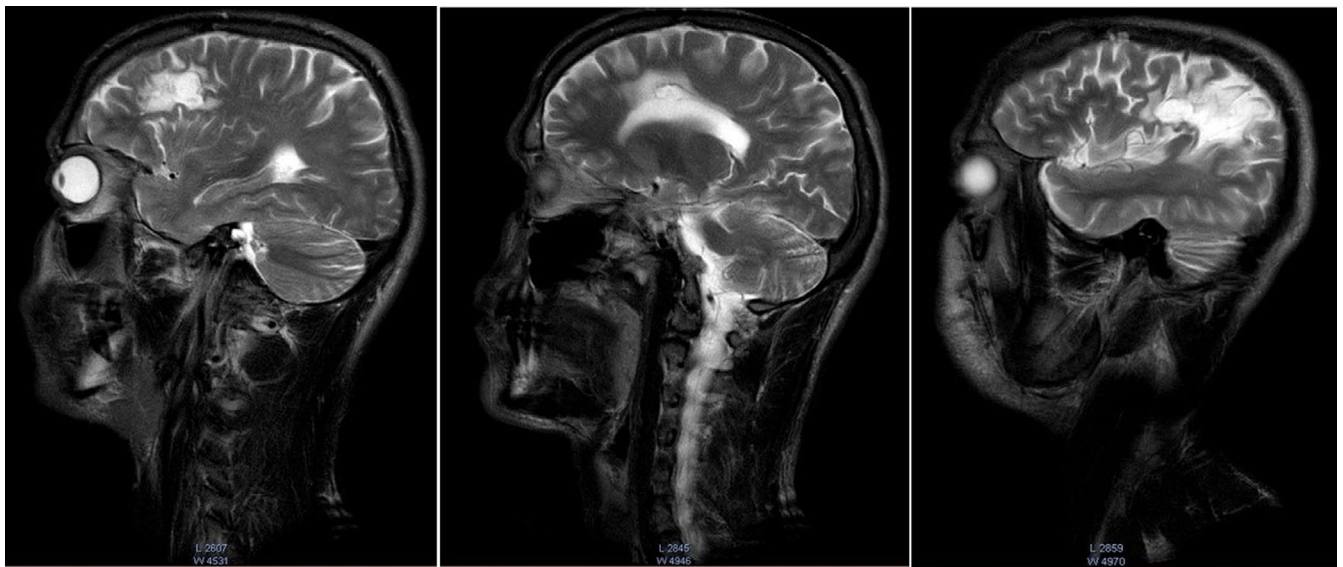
Sagittal T2-weighted TSE images depicting the intracranial trajectory of the bullet. Left inset: entry wound; middle inset: intracranial trajectory with the bullet transiting slightly above the callosal structures; right inset: exit wound
